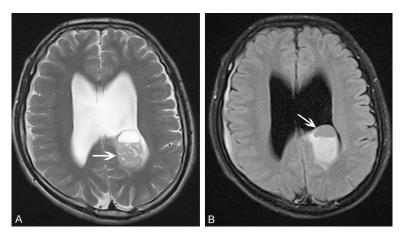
MRI presentation of the tumor. A, B. MRI revealed a solid and cystic mass in the posterior horn of the left ventricle.
